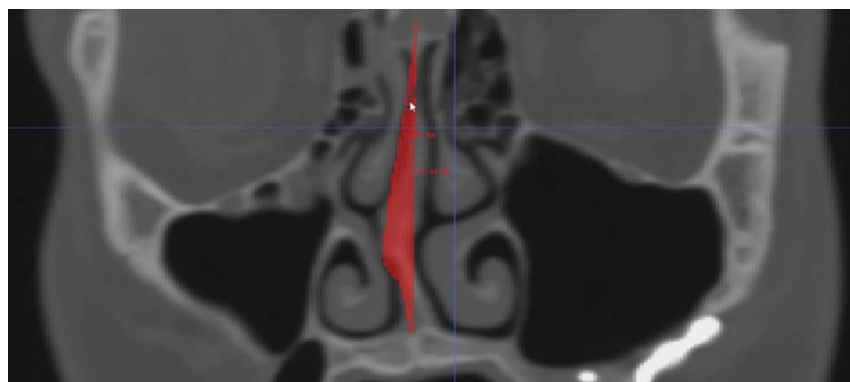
Delineated area for a single CBCT section.
